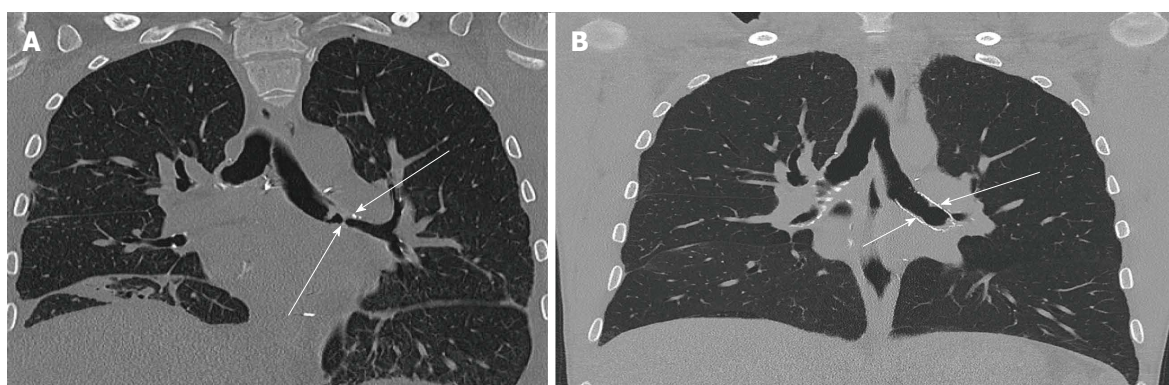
Computerised tomography scan of the chest showing a left main stem bronchial stenosis (arrow) in a 36-year-old male 2 mo post lung transplantation. A: Coronal slice of CT chest image before insertion of bronchial stent; B: Coronal slice of CT chest image after insertion of bronchial stent. CT: Computerised tomography.
